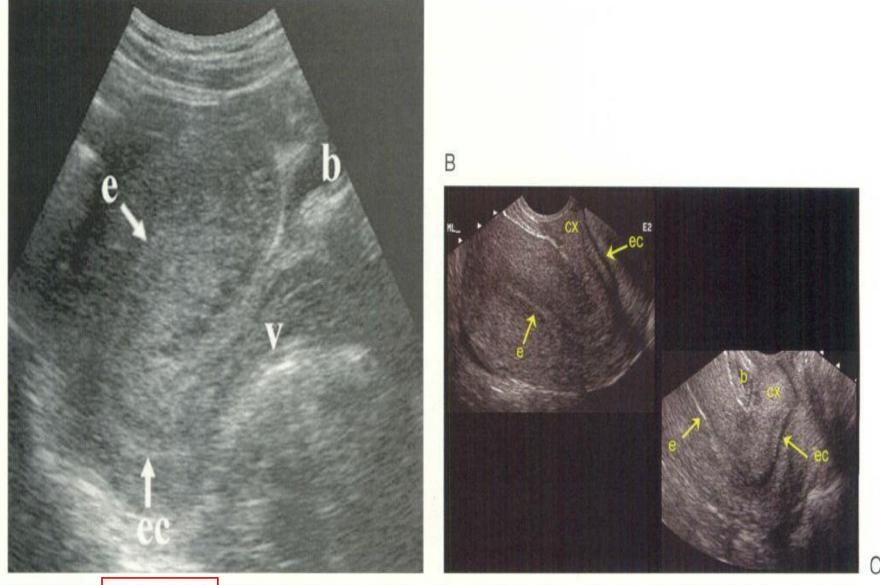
Anteflexed uterus. A. Transabdominal sonogram in the midline sagittal plane through the uterus. The bladder (b) is almost completely empty. v, vagina. B. Transvaginal midsagittal scan of an anteflexed uterus. C. Transvaginal scan of the cervix and lower uterine segment. The bladder (b) is almost empty. The endocervical canal (ec) and endometrial canals (e) form an angle of approximately 90 degrees in all three images.
